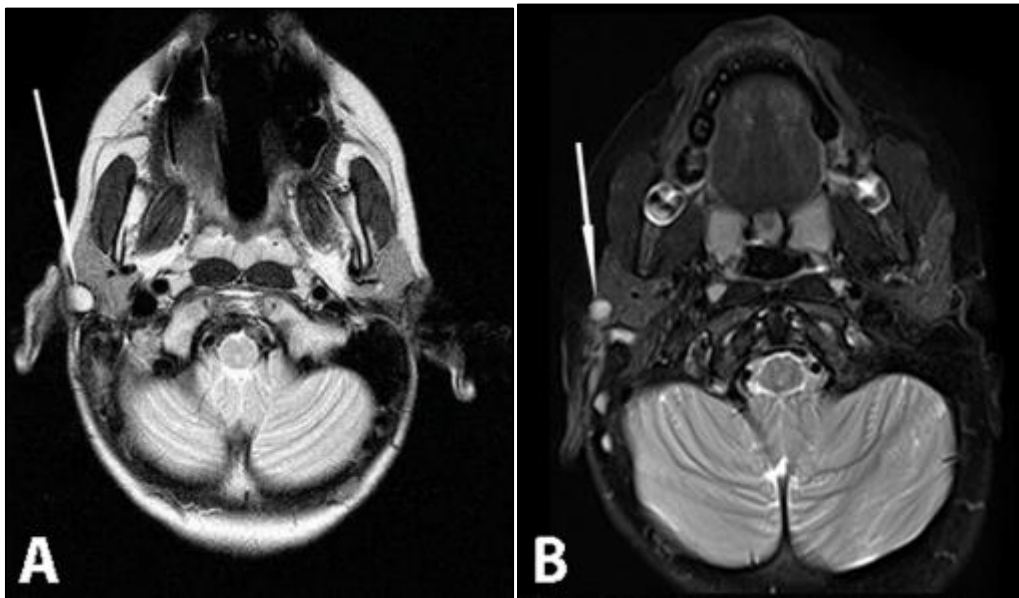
MRI findings of the fistulous tract in the right parotid region. A: T1-weighted image showing a hypointense tubular tract extending toward the skin opening, with a cystic formation indicated by the arrow. B: T2-weighted image revealing the same tract with hyperintensity, consistent with fluid-filled structures, and the cystic formation again indicated by the arrow
